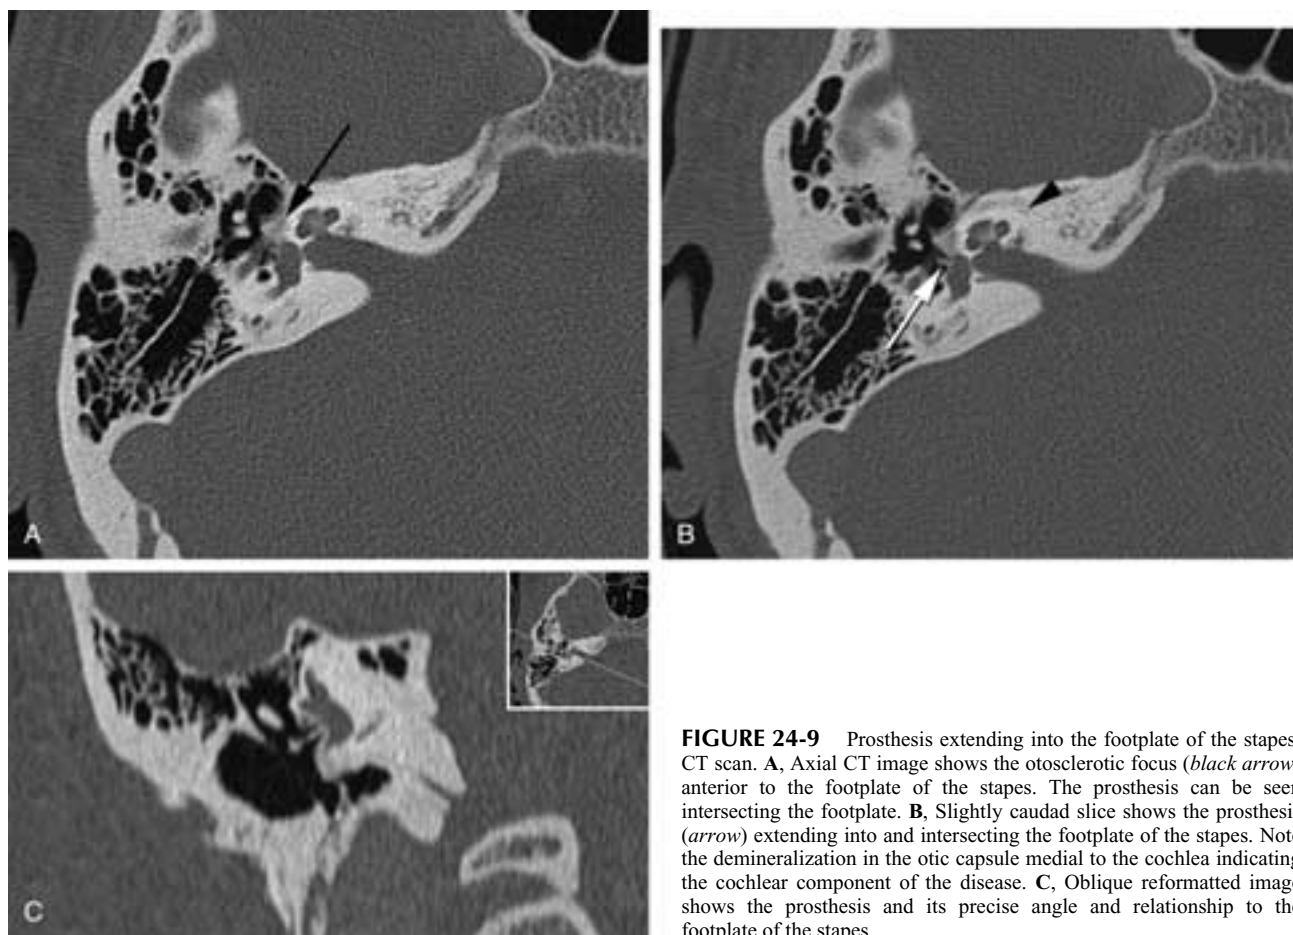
Prosthesis extending into the footplate of the stapes, CT scan. A, Axial CT image shows the otosclerotic focus (black arrow) anterior to the footplate of the stapes. The prosthesis can be seen intersecting the footplate. B, Slightly caudad slice shows the prosthesis (arrow) extending into and intersecting the footplate of the stapes. Note the demineralization in the otic capsule medial to the cochlea indicating the cochlear component of the disease. C, Oblique reformatted image shows the prosthesis and its precise angle and relationship to the footplate of the stapes.
